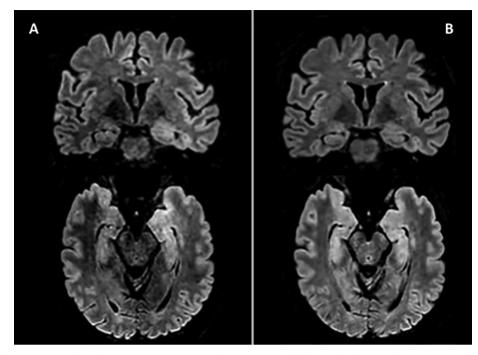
BRAIN MRI. First brain MRI (panel A) showing asymmetric FLAIR-hyperintensity of the left medial temporal cortex associated with mild gyral expansion. Second brain MRI (panel B) with complete resolution of cortical hyperintensity.
